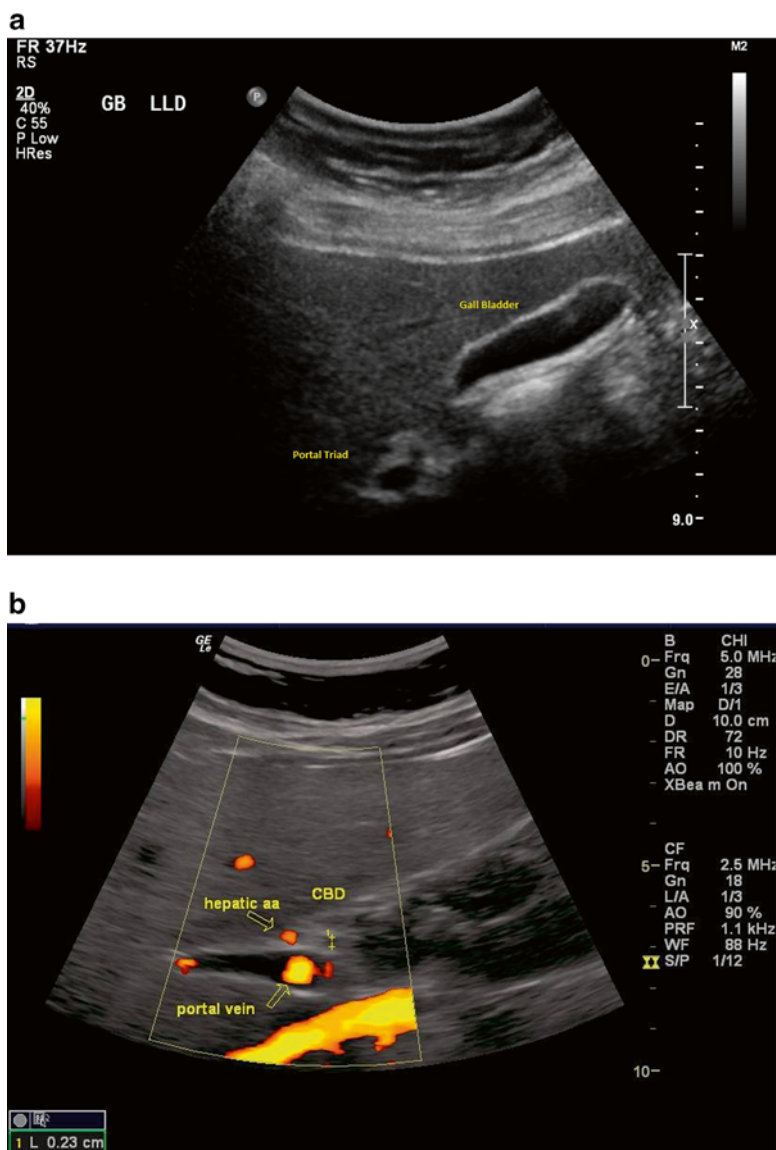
(a, b) The portal triad visualized with B Mode (a) inferior to the gall bladder and zoomed in with power Doppler mode (b). Hepatic aa=hepatic artery. CBD common bile duct
